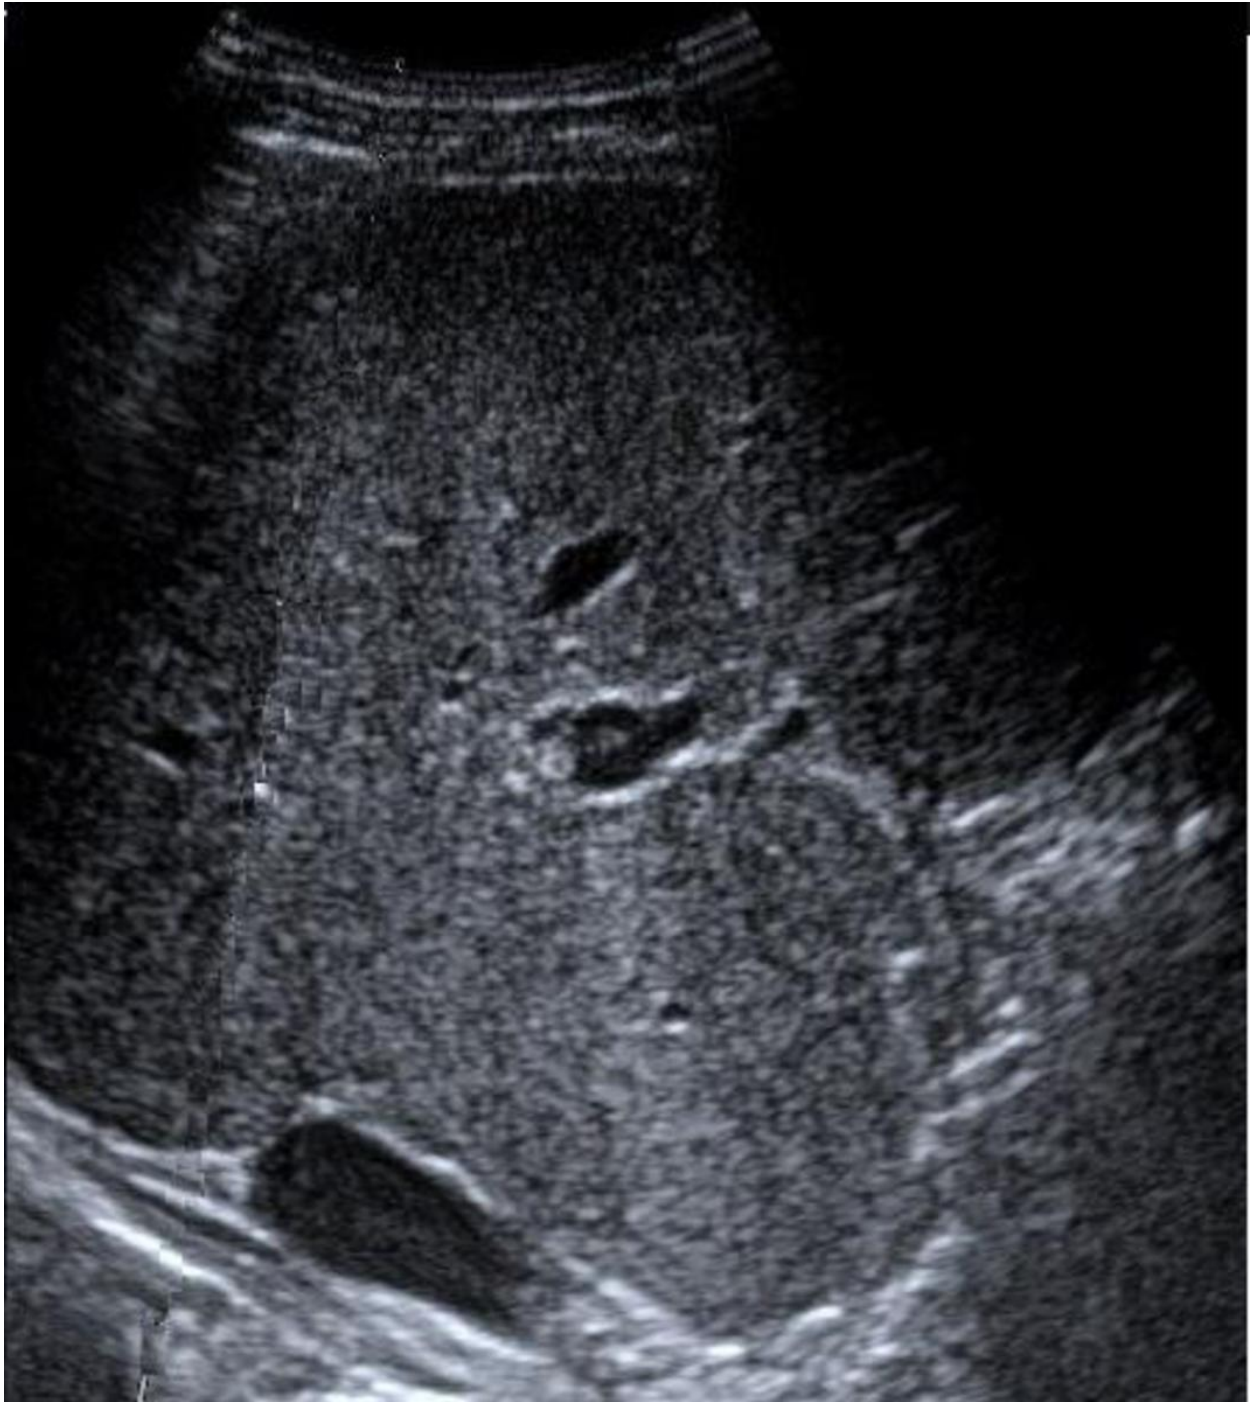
Ultrasound image showing an enlarged caudate lobe, a sign seen in half of the patients with Budd-Chiari Syndrome.
